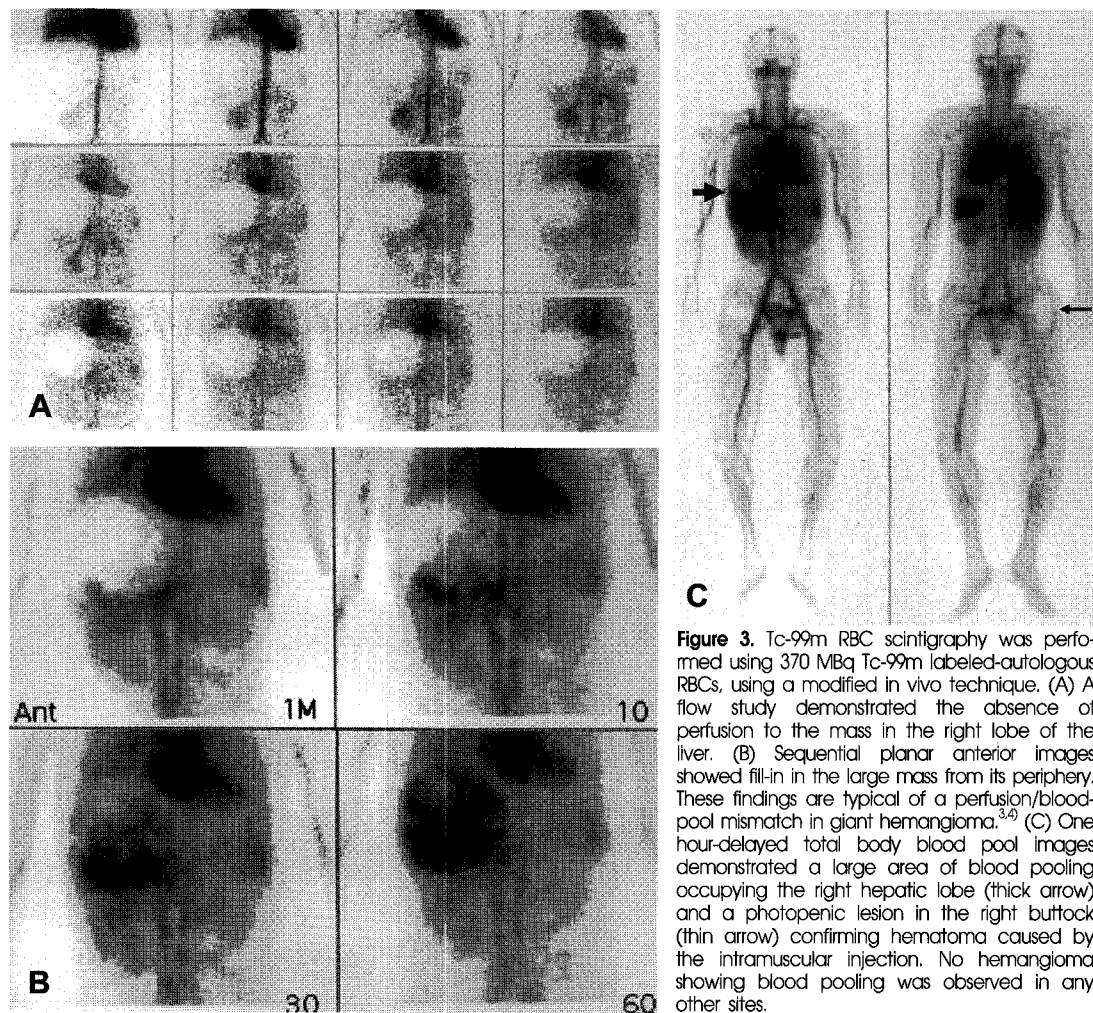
Tc-99m RBC scintigraphy was performed using 370 MBq Tc-99m labeled-autologous RBCs, using a modified in vivo technique. (A) A flow study demonstrated the absence of perfusion to the mass in the right lobe of the liver. (B) Sequential planar anterior images showed fill-in in the large mass from its periphery. These findings are typical of a perfusion/blood-pool mismatch in giant hemangioma.^{3,4} (C) One hour-delayed total body blood pool images demonstrated a large area of blood pooling occupying the right hepatic lobe (thick arrow) and a photopenic lesion in the right buttock (thin arrow) confirming hematoma caused by the intramuscular injection. No hemangioma showing blood pooling was observed in any other sites.
